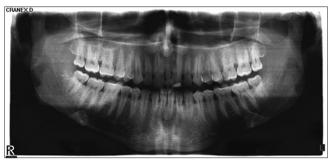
Radiographic image of mesiodense
